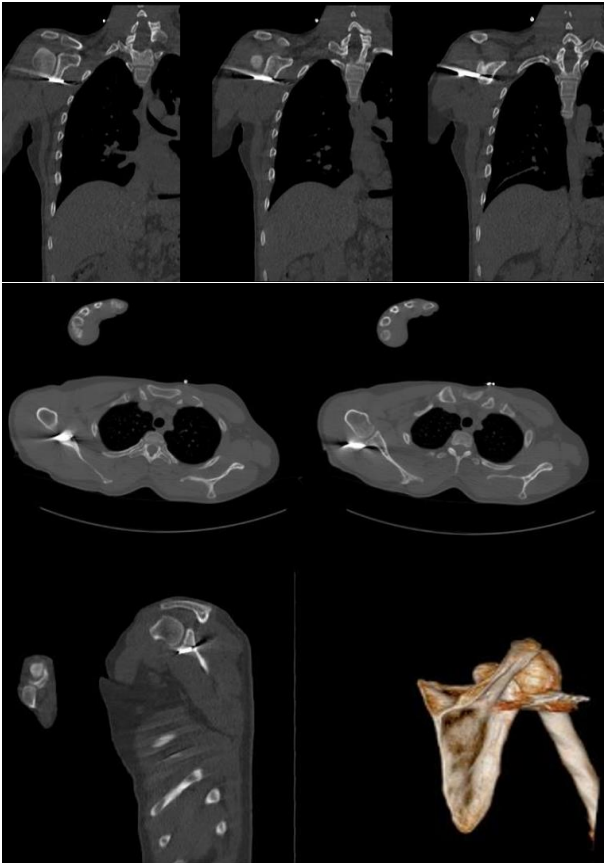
Computed tomography (CT) scan of the right shoulder
